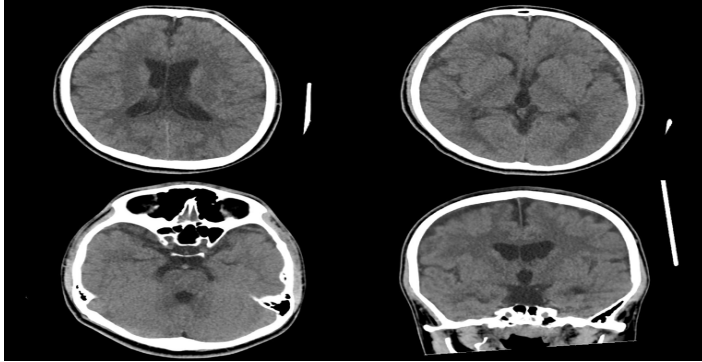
Simple head Computerized Tomography (CT): there are non-specific findings at ventricular level and no subdural collections.
